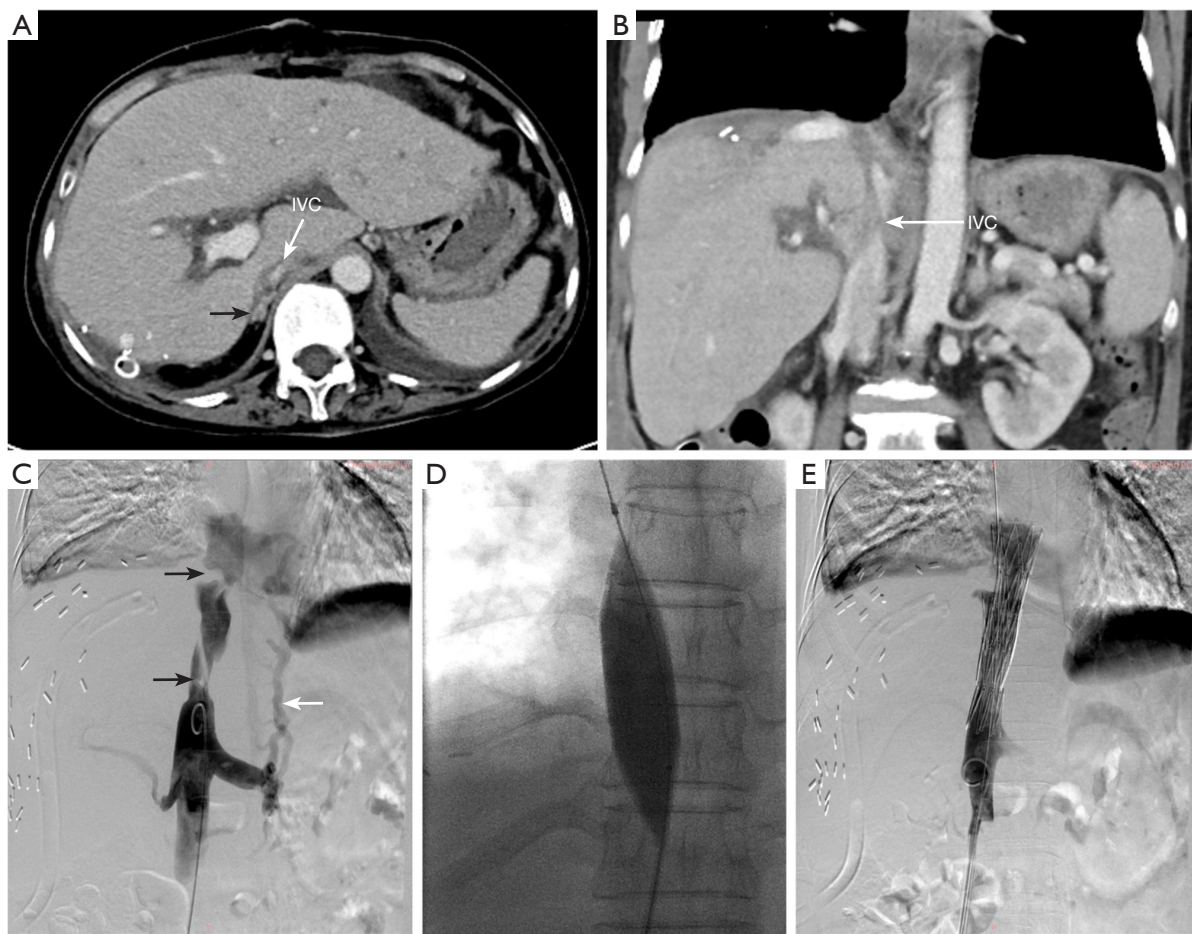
IVC stenosis after liver transplantation. Postoperative abdominal CT scan: (A) stenosis of the IVC below the suprahepatic IVC anastomosis (white arrow), and engorgement of the paravertebral plexus and azygos vein (black arrows) were observed; (B) stenosis of the IVC on a coronal image (white arrow). Inferior vena cavography: (C) twisted-shape stenosis of the IVC between the supra- and infrahepatic IVC anastomosis (black arrows), and multifocal collateral flows draining into the right atrium (white arrow); (D,E) after balloon angioplasty, a 2.5 cm × 7.5 cm bare stent was released in the thoracic 12-lumbar 1 vertebral segment, and a 3.0 cm × 7.5 cm stent was placed in the proximal segment. Collateral veins disappeared. IVC, inferior vena cava; CT, computed tomography.
